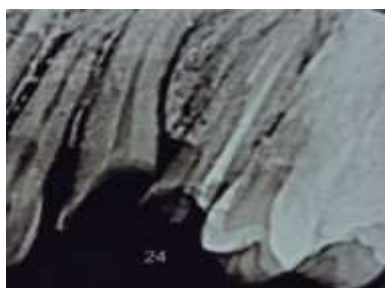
A periapical radiograph verified the remaining apical gutta-percha after post space preparation
